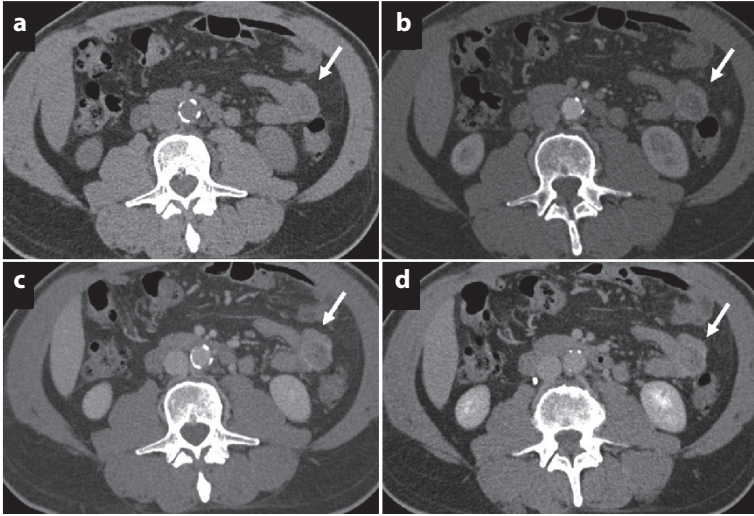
A 54-year-old man with a history of abdominal pain. (a) Axial unenhanced CT scan shows a rounded isoattenuating mass in the ileum (*arrow*), not easily detectable. The axial arterial (b), portal (c) and delayed (d) phases show ring enhancement (*arrows*) due to the presence of necrosis within the lesion
